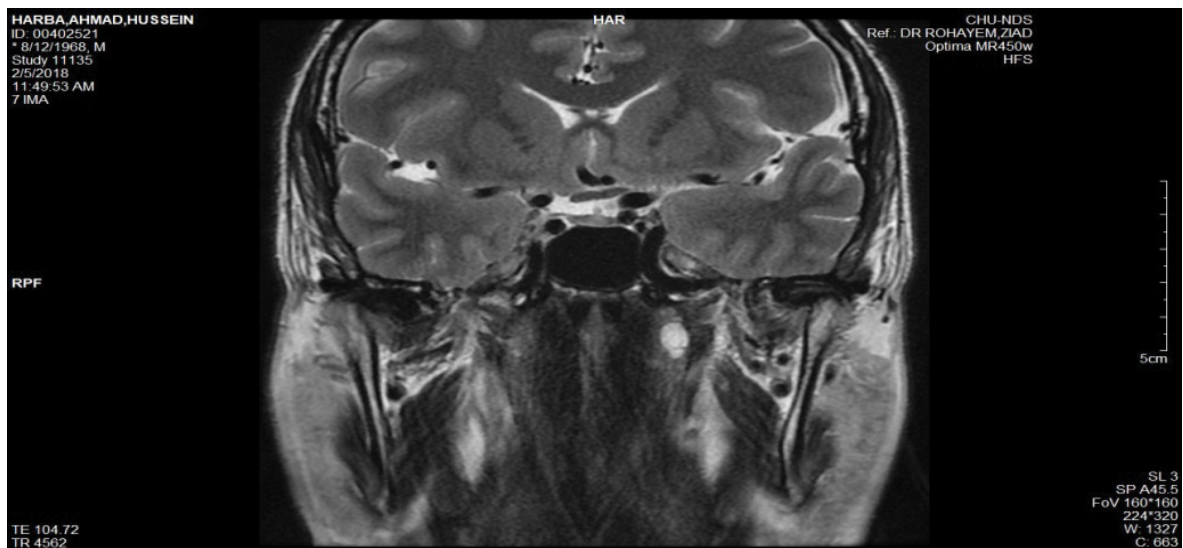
Coronal cut of Brain MRI in T2 showing cystic lesion in the left Eustachian tube.
